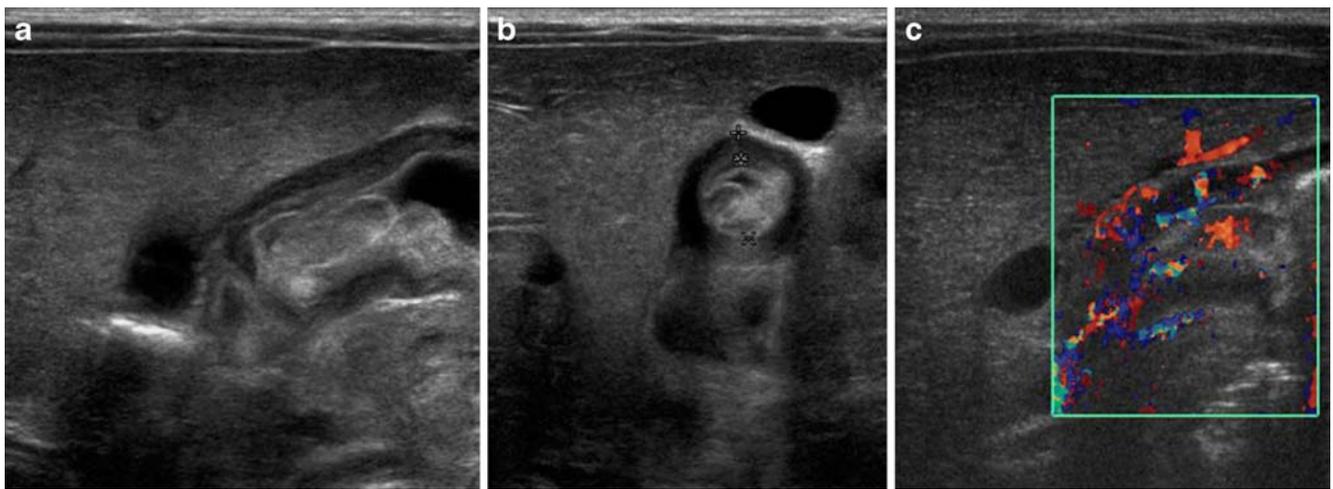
Longitudinal (a) transverse (b) and Doppler (c) US images through the abnormal pylorus, outlining the increased vascularity to the thickened muscle measuring approximately 3.6 mm, and to the thickened mucosa, which fills and obstructs the 10.7 mm wide
